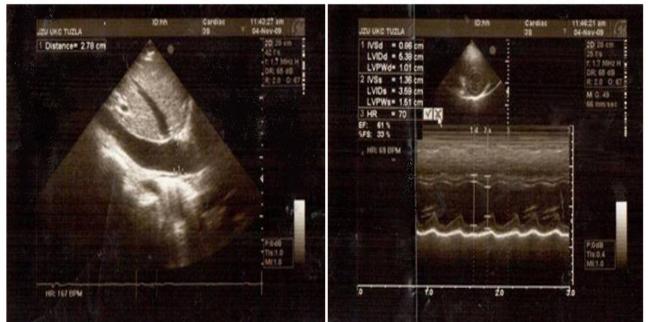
Echocardiography longitudinal section of VCI and parasternal cross-section at the level of mitral valves
